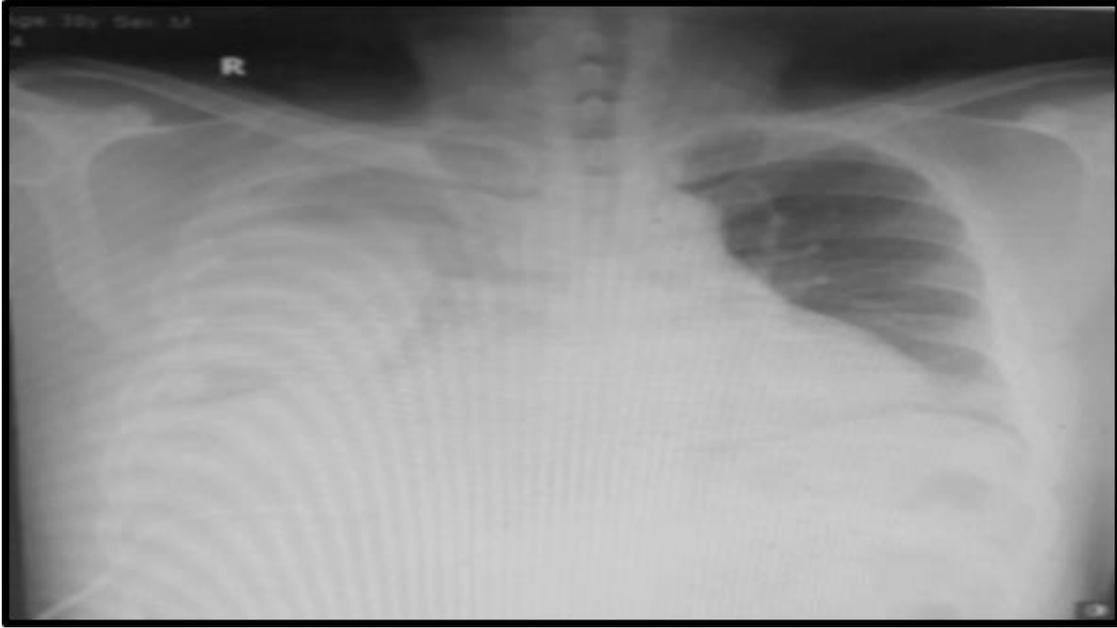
Chest X-ray showing right-side pleural effusion.
